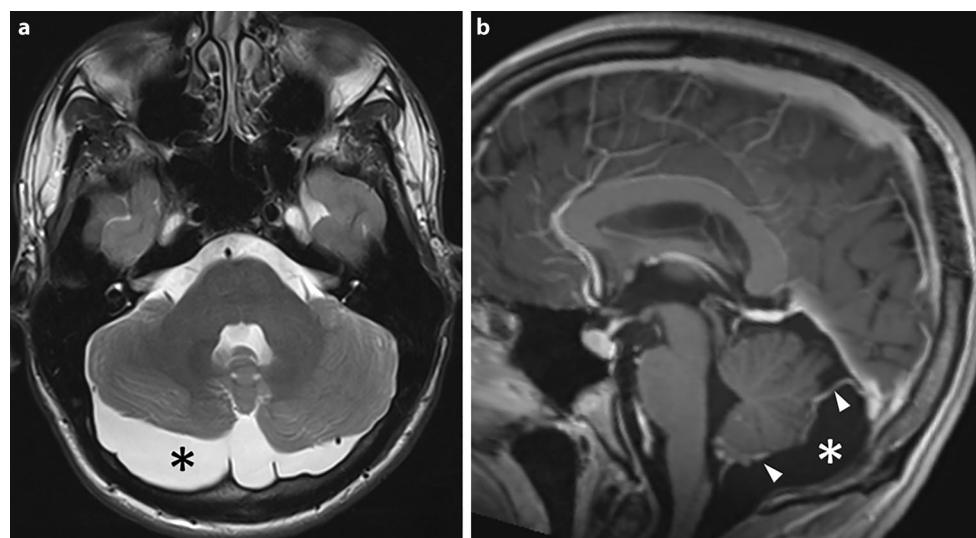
a, b Mid-sagittal T2-weighted turbo spin echo (TSE) (a) and coronal triple inversion recovery (TIR) sequence (b) images from 1.5T magnetic resonance imaging in a 2-month-old female patient scanned for a posterior fossa cyst incidentally found by sonography on the first day of life. The *asterisks* indicate a space-occupying infracerebellar arachnoid cyst. Besides being asymmetrically compressed and slightly elevated, the cerebellum appears normal in structure. The overlying skull shows thinning and scalloping. Within a follow-up period of 5 years, the girl showed normal neurological development
